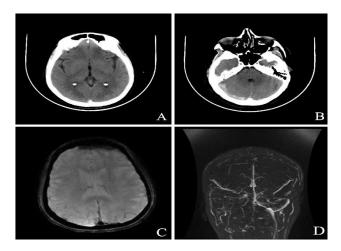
(A) Non enhanced CT (NCCT) brain, axial section showing hyperdense posterior superior sagittal sinus; (B) NCCT brain, axial section showing hyperdense thrombus in the right transverse sinus; (C) MRI brain, susceptibility weighted imaging (SWI) sequence, axial section showing increased susceptibility signals within the posterior part of the superior sagittal sinus; and (D) phase contrast MRV, reconstructed image showing thrombosis of superior sagittal sinus, bilateral transverse sinus, right sigmoid sinus and internal jugular vein.
